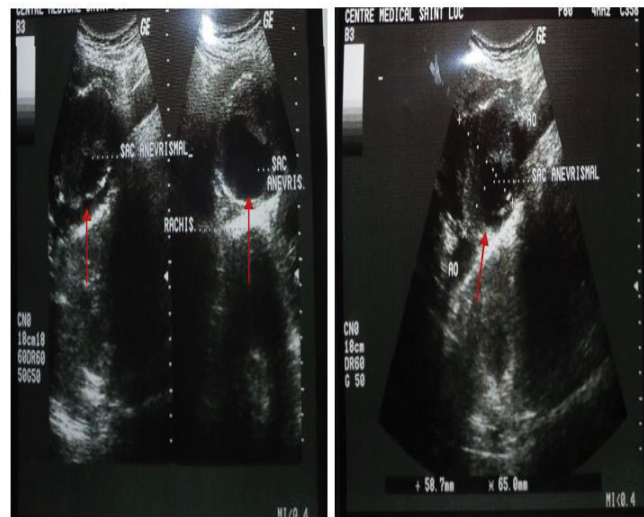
Abdominal ultrasound showing a huge aneurysm sac.
